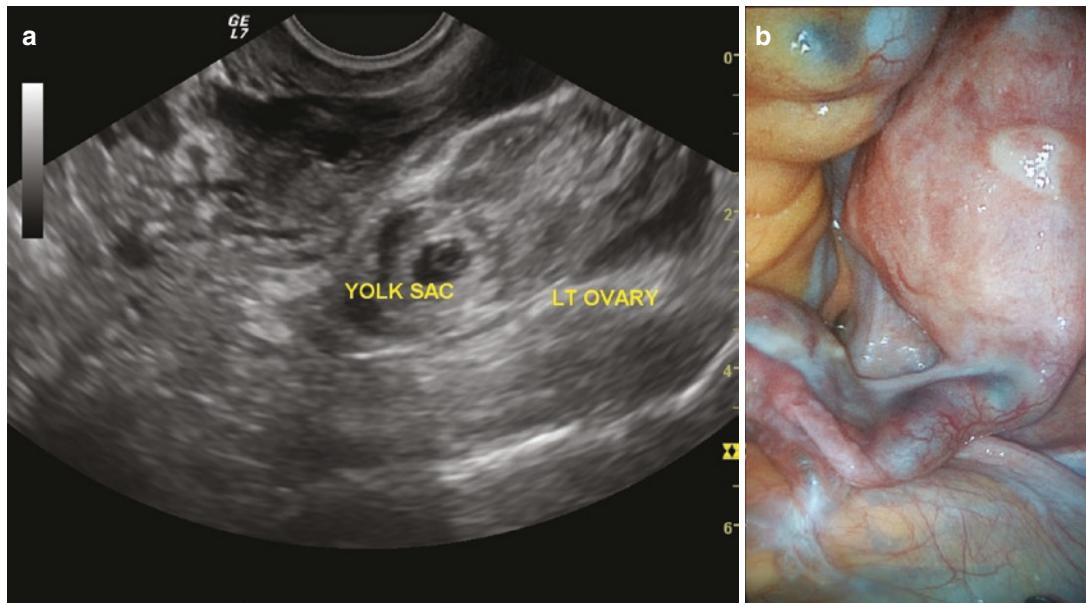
(a) An ultrasonographic image showing a left heterotopic tubaric pregnancy. (b) A laparoscopic image of a right tubal pregnancy
